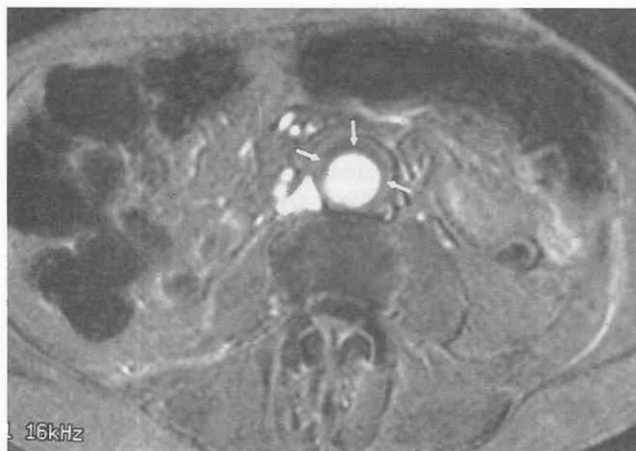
Endoaneurysmorrhaphy shortly after aortic aneurysm repair. Gradient-echo MR image reveals the high signal intensity of flowing blood within the aortic graft, but the blood and fluid between the graft and the native aorta (arrows) demonstrate low signal intensity. Normally, within about 3 months of surgery, most of the fluid between the graft and the aneurysm wrap is resorbed.
